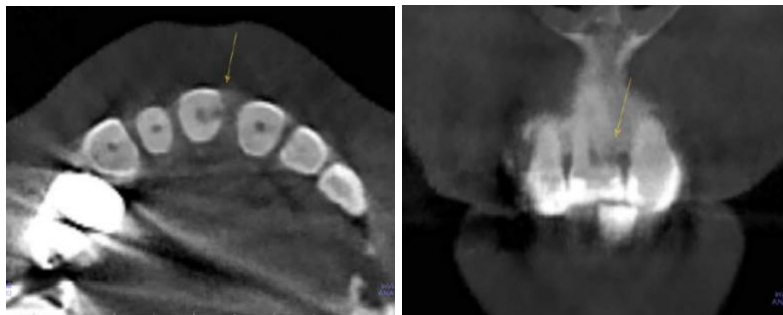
Axial (left) and coronal (right) CBCT cross-sections demonstrating external cervical resorption at the mesial aspect of the tooth #8 with pulpal involvement
